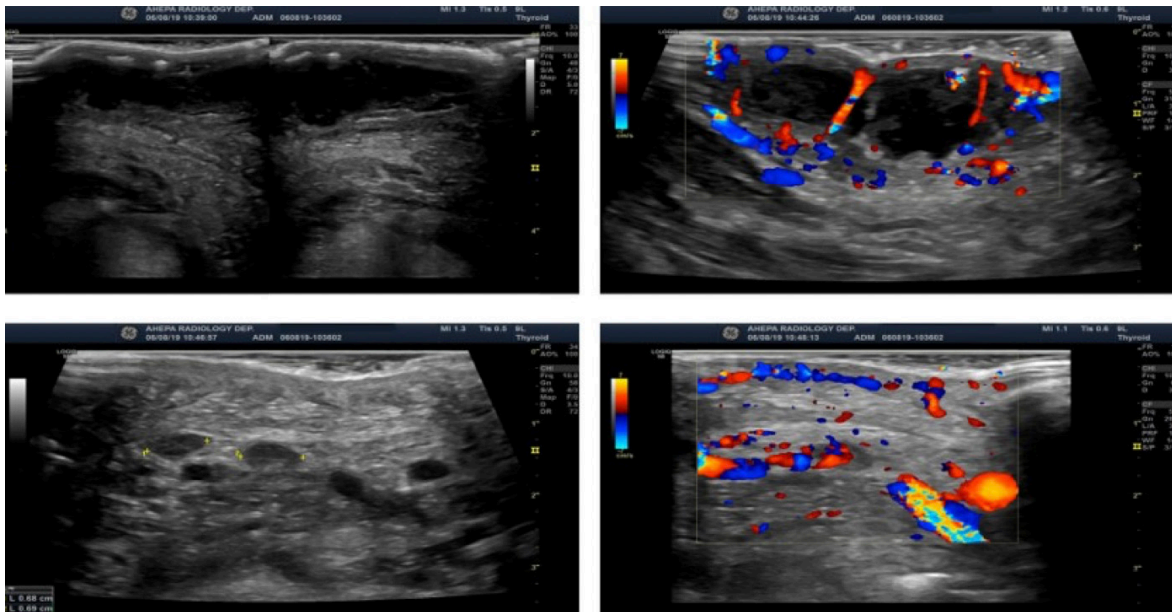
USG images show an abscess of the submandibular area with a thickened wall and increased vascularity with the use of color Doppler. Multiple, slightly rounded superficial lymph nodes with a reactive image, intense skin cellulitis and increased hemorrhage.
